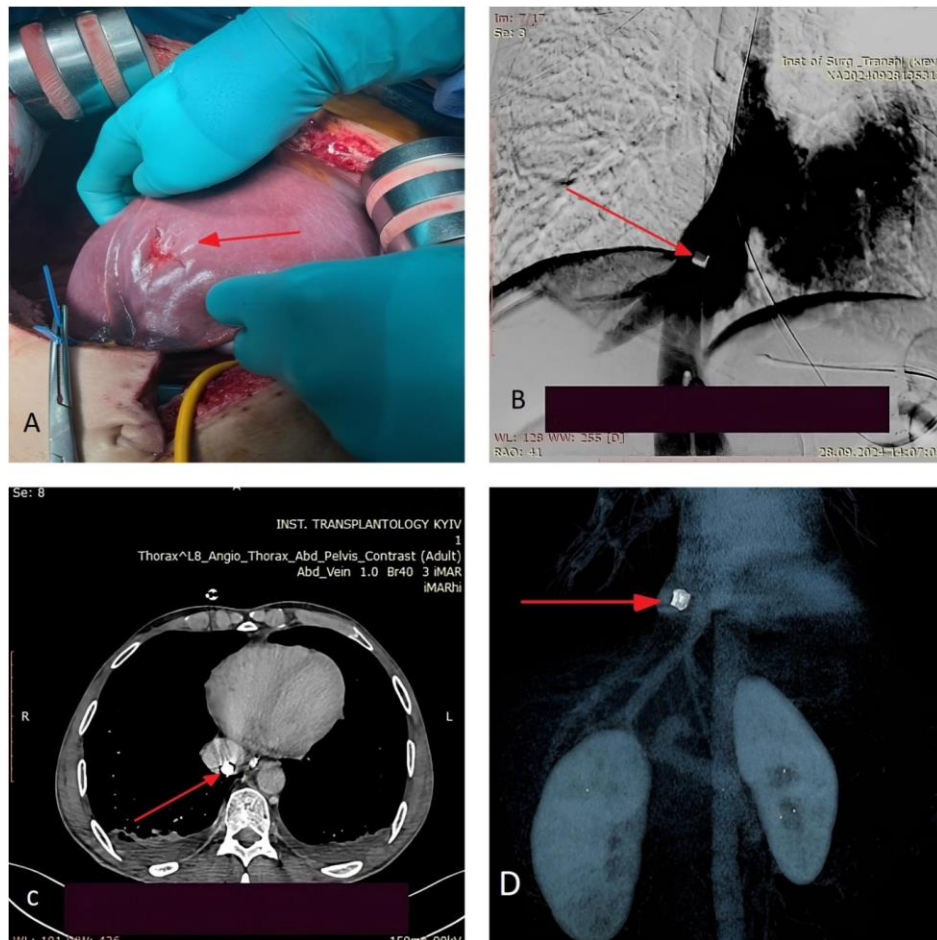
(A) Entry wound in the right liver lobe (arrow). (B) IVC venography showing the fragment in the supradiaphragmatic IVC (arrow). (C) Axial contrast-enhanced CT confirming the fragment along the posterior suprahepatic IVC wall (arrow). (D) 3D-CT reconstruction showing fragment position relative to major vessels (arrow).
